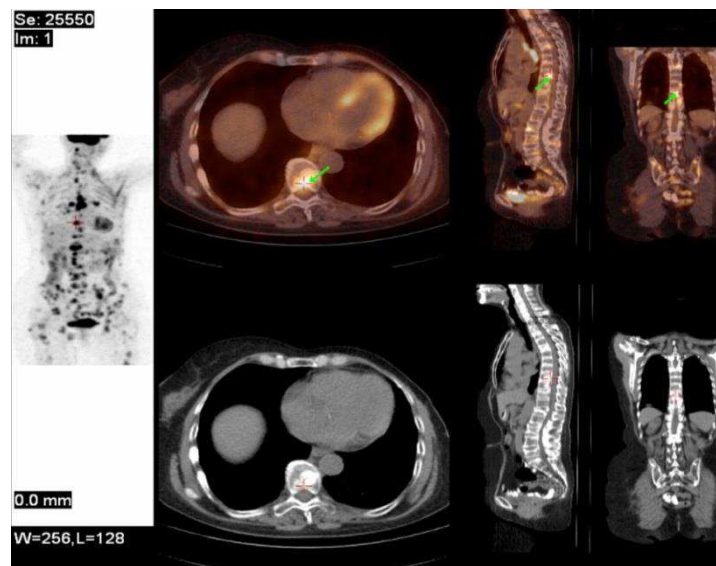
Radionuclide distribution of  $^{18}\text{F}$  (FDG) in the patient's body showed multiple metastatic center, including in vertebral bodies (indicated by an arrow)
